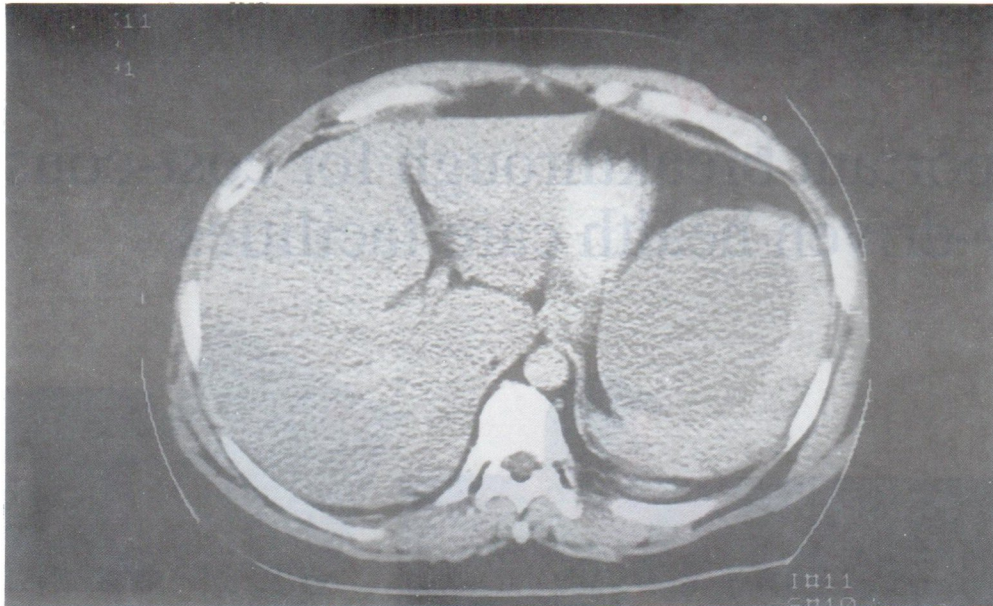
Computed tomography scan revealed a large cyst in the spleen with partial rim calcification.
